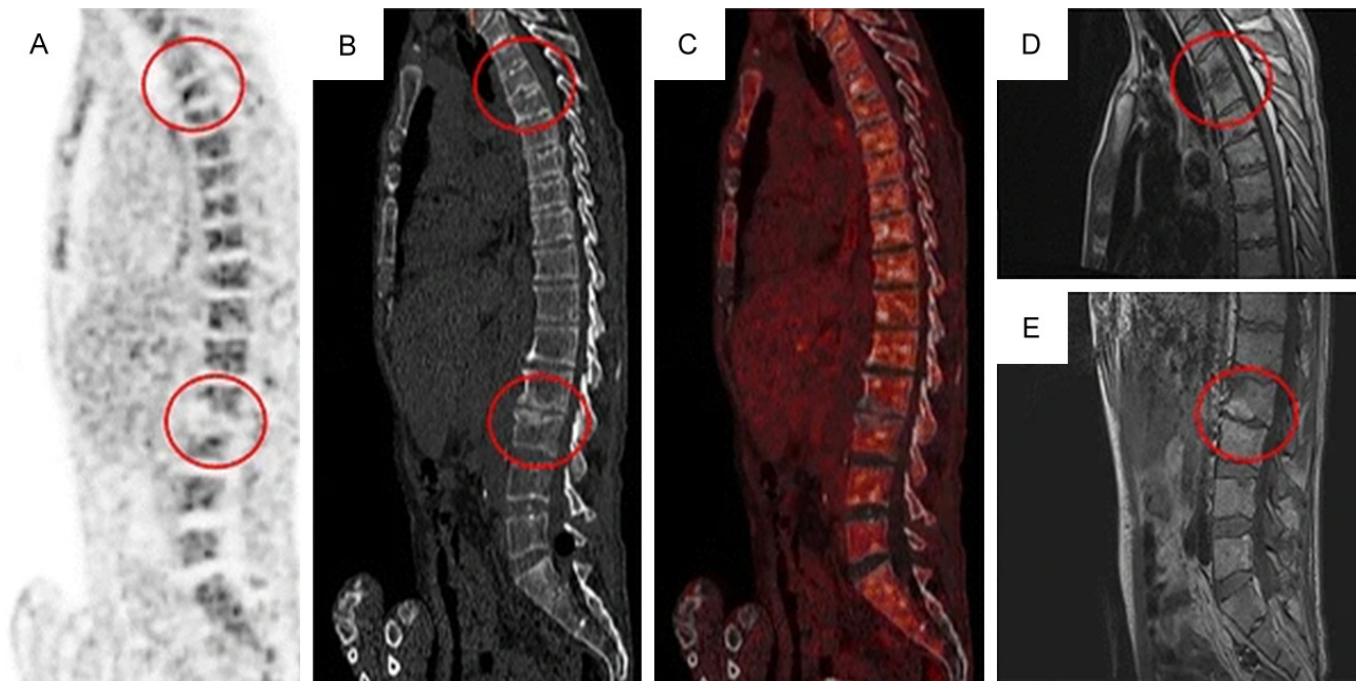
Spinal imaging in a 61-year-old man admitted with *S. aureus* endocarditis and back pain. (A) ^{18}F -FDG-PET, (B) CT, and (C) ^{18}F -FDG-PET/CT show degenerative changes at T3-T4 and L2-L3. (D, E) Pre- and post-contrast T1-weighted Gd-enhanced MRI show Modic type 1 changes at the same levels. Initial MRI reported vertebral osteomyelitis at T3-T4 and L2-L3, while PET/CT was negative. On reevaluation, both modalities were negative, and long-term follow-up indicated that the back pain was attributable to degenerative changes. Reproduced from [32] under Creative Commons Attribution 4.0 International License.
